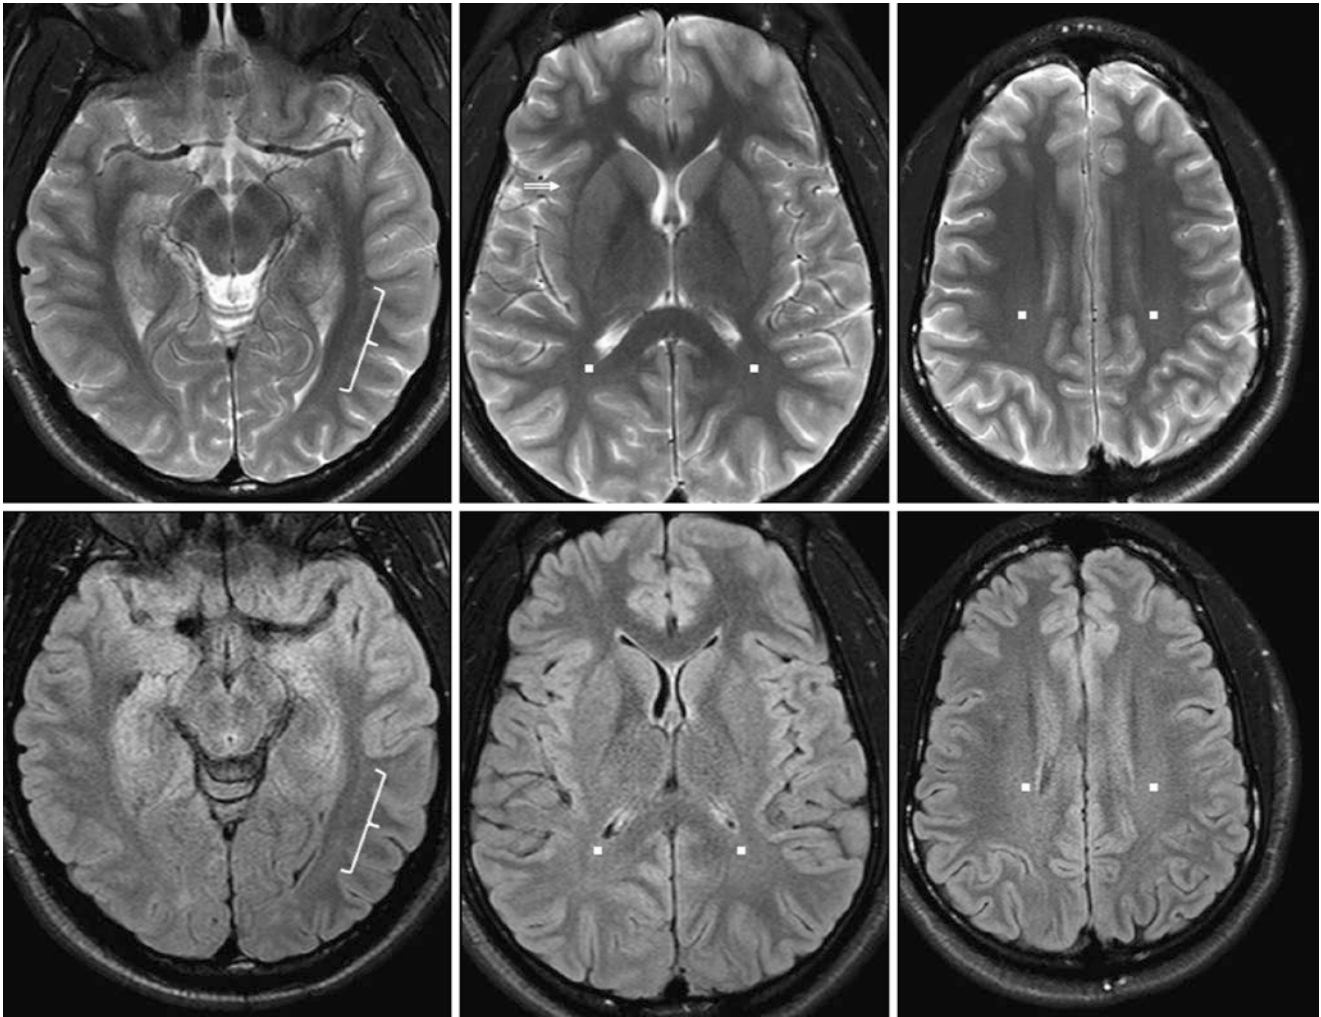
A 19-year-old with chronic daily headaches had a normal 3T MRI with SE T2WI (*top row*) and FLAIR images (*bottom row*), which depict very subtle terminal zones within the optic radiations
